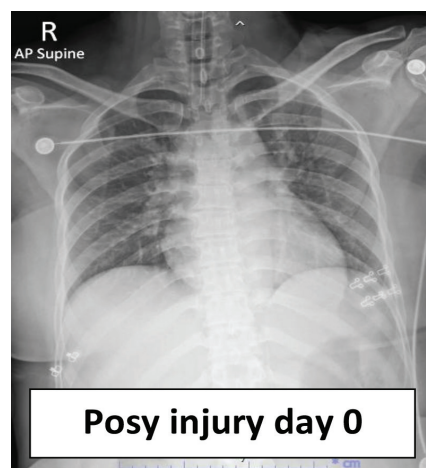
Chest X-ray with unremarkable findings
